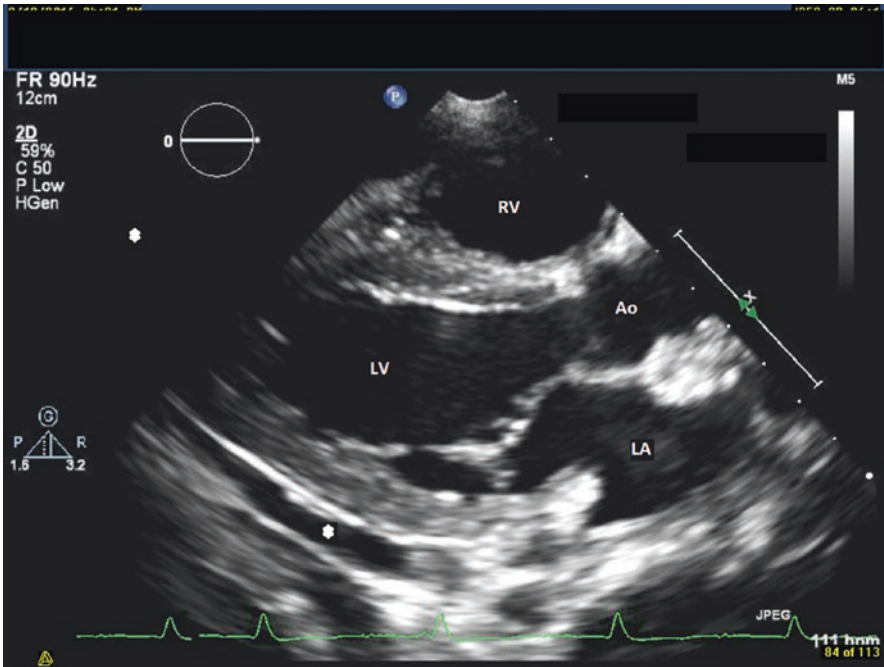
A small posterior pericardial effusion (asterisk) behind the left ventricle as visualized from the parasternal long-axis view showing
